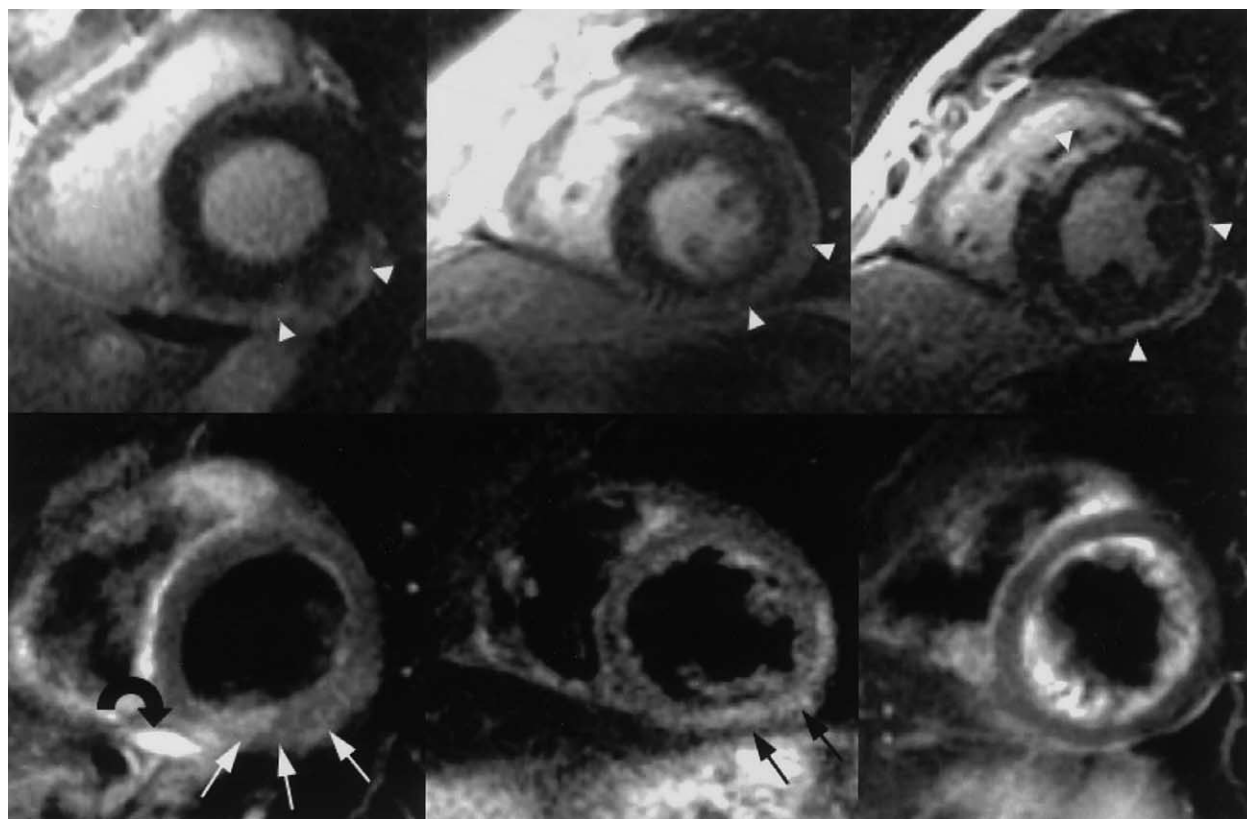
Representative images from 3 patients (#8, #12, and #14 from left to right, respectively). (Top) Late gadolinium enhancement (LGE). (Bottom) T2-weighted. Focal high T2 signal (thin arrows) corresponds to areas of LGE (arrowheads) in Patients #8 and #12 but not in Patient #14. Note the predominant epicardial distribution of high T2 signal in Patient #12. Small pericardial effusion is seen in Patient #8 (thick curved arrow).
